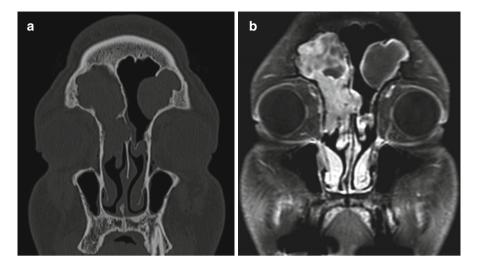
(a) Coronal bone window CT scan demonstrates complete right frontal opacification in patient with known chronic granulomatous fungal rhinosinusitis (b). T1- weighted MRI with contrast demonstrates enhancing lesion in the *right* frontal sinus. In contrast, the *left* frontal sinus has a mucous retention cyst
